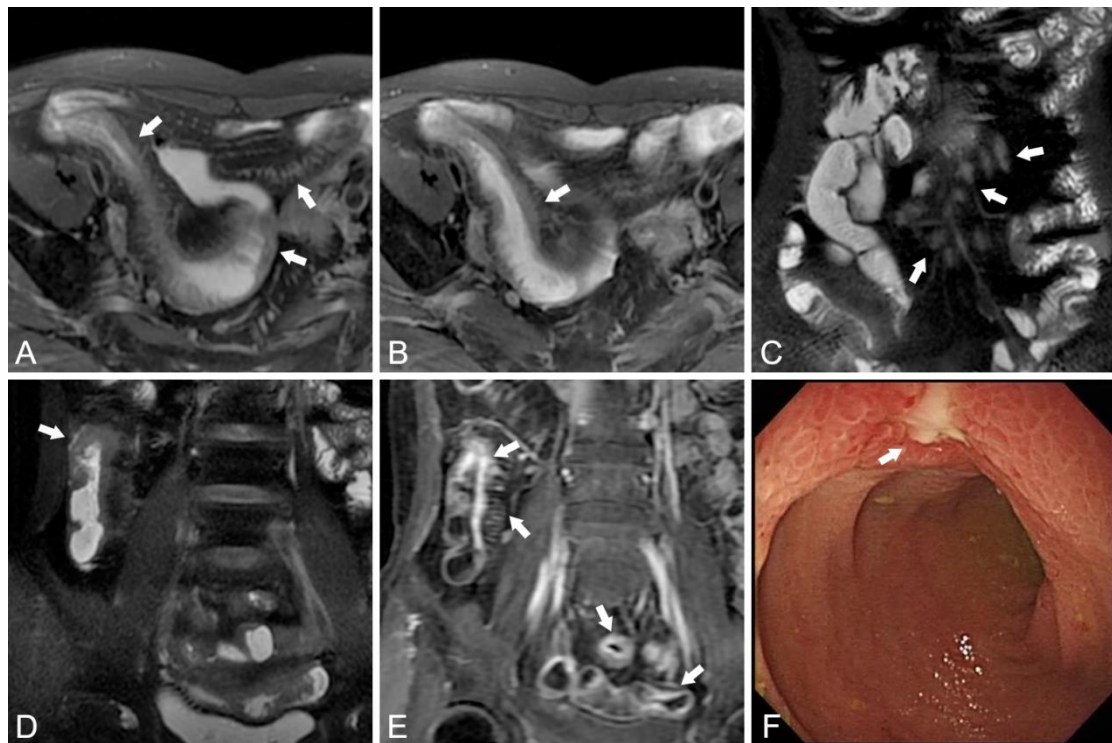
Conventional MRE findings in the distal ileum of a patient with small bowel CD. (A, B) Magnetic resonance axial T2-weighted images depicts mural thickening and moderate increase in signal-bowel wall of the distal ileum (arrow), indicating oedema in wall, and the presence of increased mesenteric vascularity (the “comb” sign). The mesenteric (arrow) shows multiple lymph nodes (C) and perimural tissue (arrow) shows a small rim of fluid (D). E, The affected bowel-wall shows marked enhancement (arrow) after intravenous administration. F, The enteroscopy
